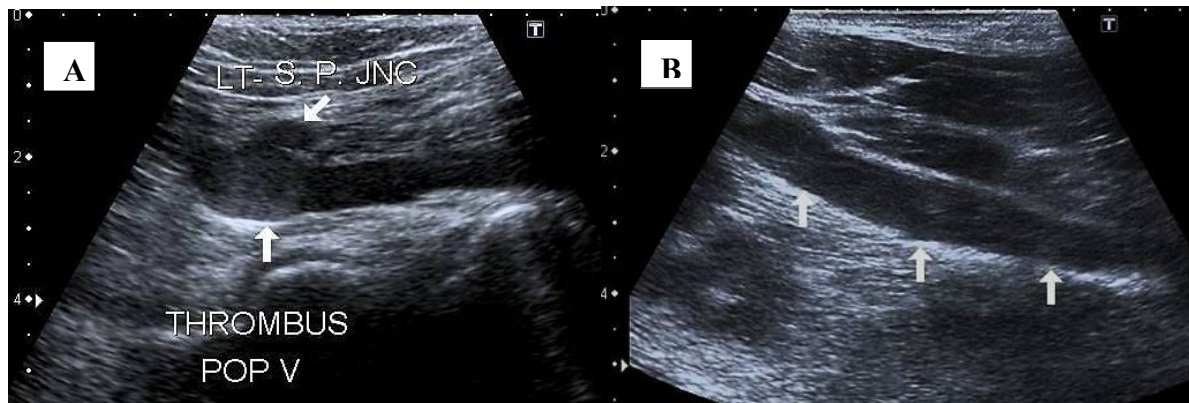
(A & B) A case of 52-year-old male with severe COVID-19 pneumonia with acute onset of lower limb pain. Left lower limb doppler (A) axial image showing thrombus in the popliteal vein (white arrow) at the level of sapheno-popliteal junction (B) longitudinal section of the same thrombus filled left popliteal vein (white arrow).
